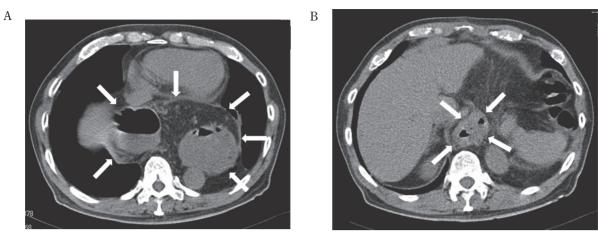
Computed tomography of the chest revealed intrathoracic stomach (arrows).
